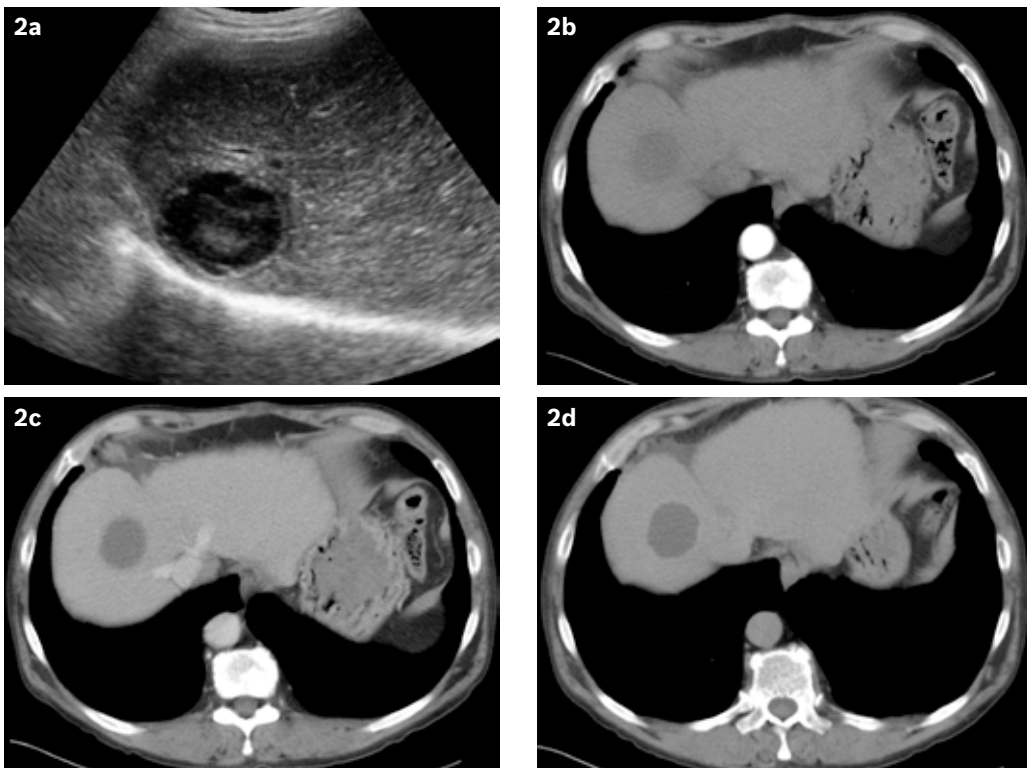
Images obtained two months after the initial presentation show cystic degeneration and mild reduction in size of the known hepatocellular carcinoma. (a) US image shows that the previously solid hepatic mass is now predominately cystic. (b) Hepatic arterial; (c) portal venous; and (d) delayed multiphase CT images performed on the same day confirm that the mass is cystic and has reduced in size. No residual areas of enhancement are seen.
